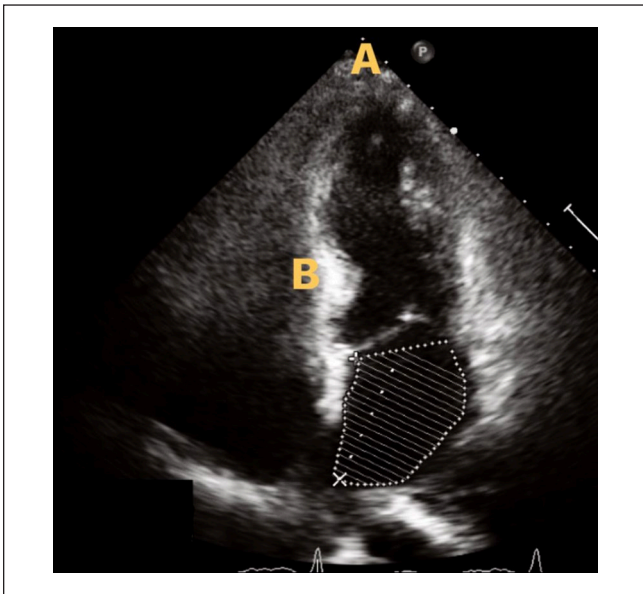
Echocardiogram reveals apical akinesis (A) and basal hyperkinesis (B) consistent with takotsubo cardiomyopathy.
